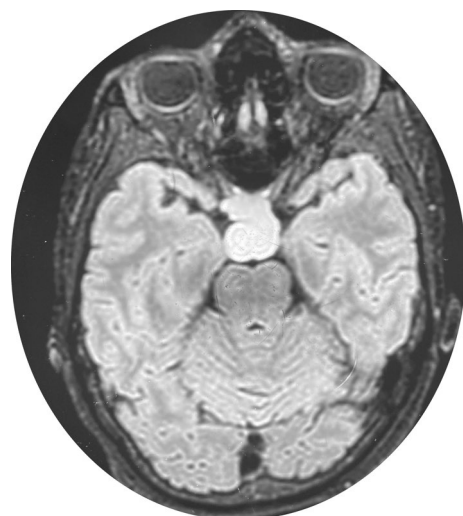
MRI brain flair sequence showing the hyperintense suprasellar lesion
